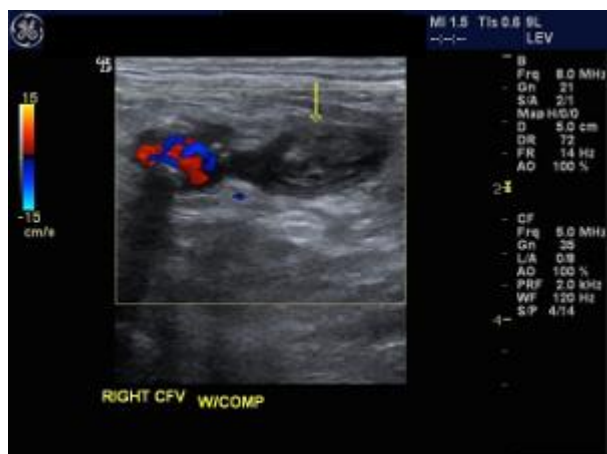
Color Doppler image of the right common femoral vein with compression.
